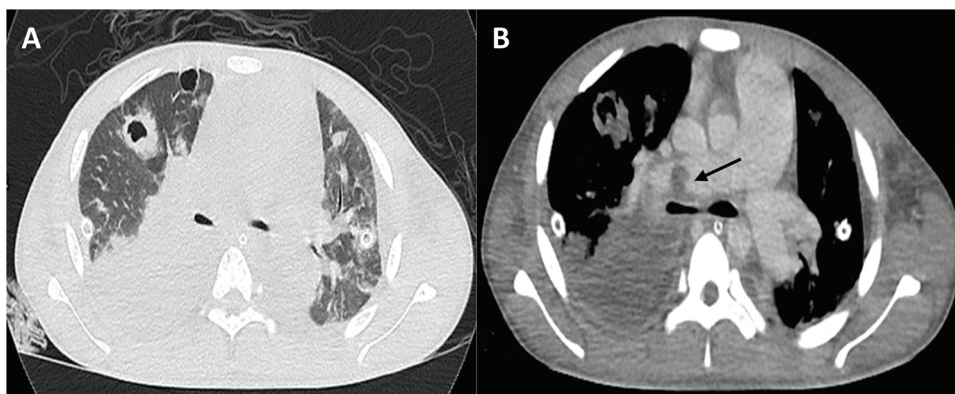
Necrotizing pneumonia with septic pulmonary embolism. (A) A lung window of chest CT shows consolidation right lung, bilateral nodules with cavities. (B) A mediastinal window of chest CT shows filling defect at right main pulmonary artery suggesting pulmonary embolism (arrow).
